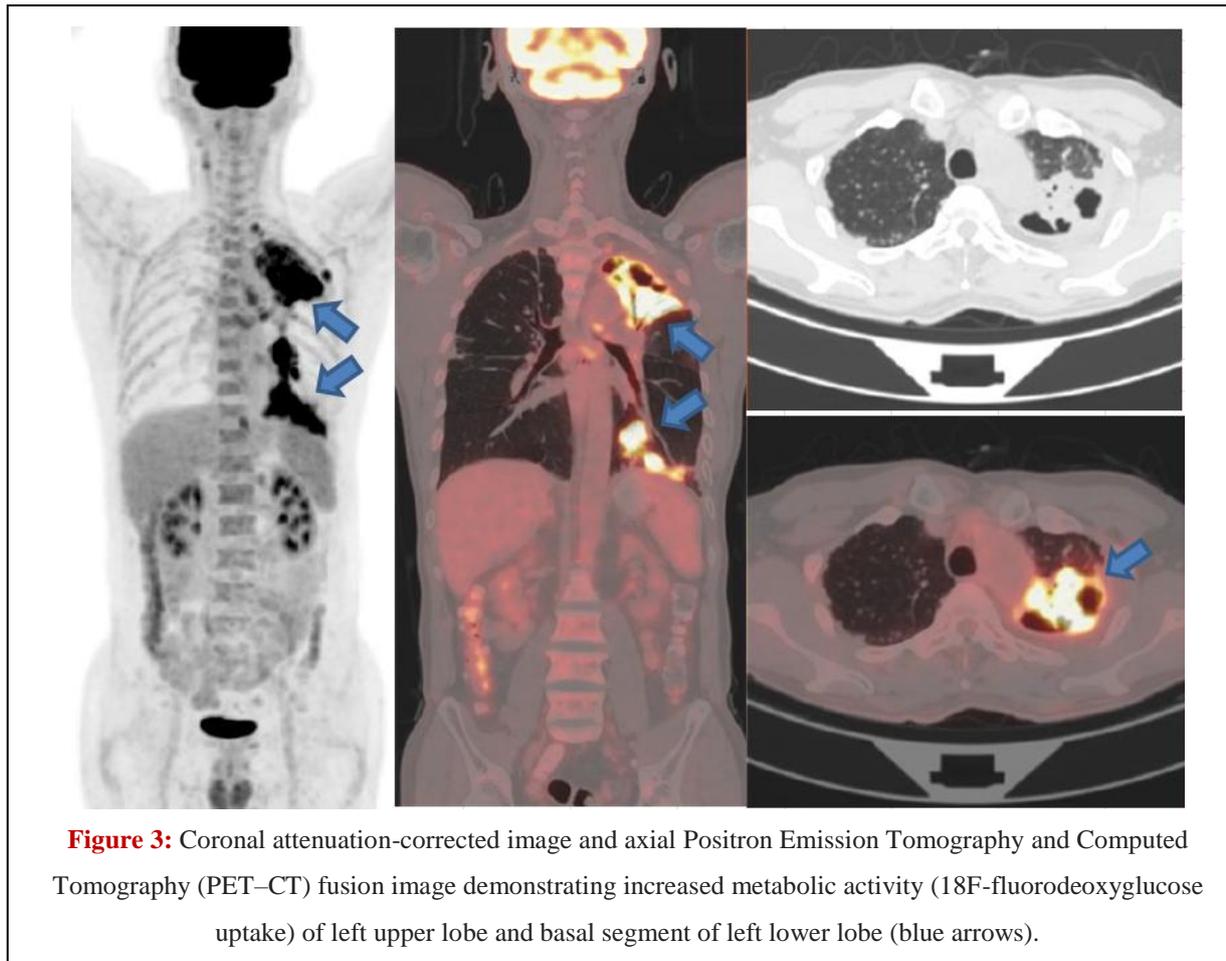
Coronal attenuation-corrected image and axial Positron Emission Tomography and Computed Tomography (PET–CT) fusion image demonstrating increased metabolic activity (18F-fluorodeoxyglucose uptake) of left upper lobe and basal segment of left lower lobe (blue arrows).
